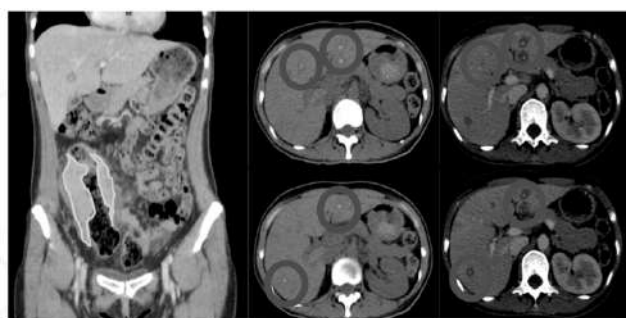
Whole Abdominal CT Scan Images
